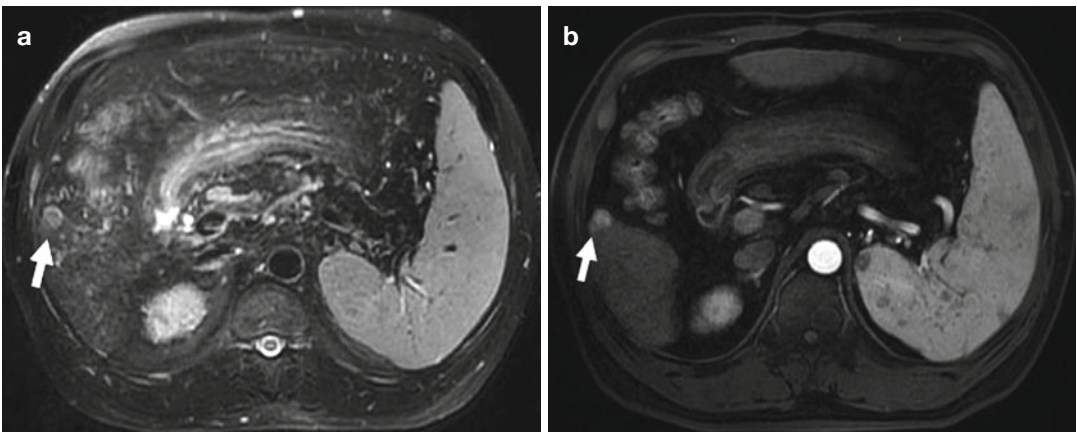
A 53-year-old man with a history of chronic hepatitis B, cirrhosis, and transcatheter arterial chemoembolization for HCC is found with a hepatic lesion (2.1 × 1.8 cm) located in the right anterior lobe and adjacent to intestine. The lesion is diagnosed to be HCC combined with history and contrast-enhanced images and treated with MWA and EA. (a) The hepatic lesion located in the right anterior lobe has high intensity and is adjacent to the intestine (*arrow*) on T2-WI MRI before treatment. (b) The hepatic lesion adjacent to intestine is highly enhanced (*arrow*) on contrast-enhanced T1-WI MRI
